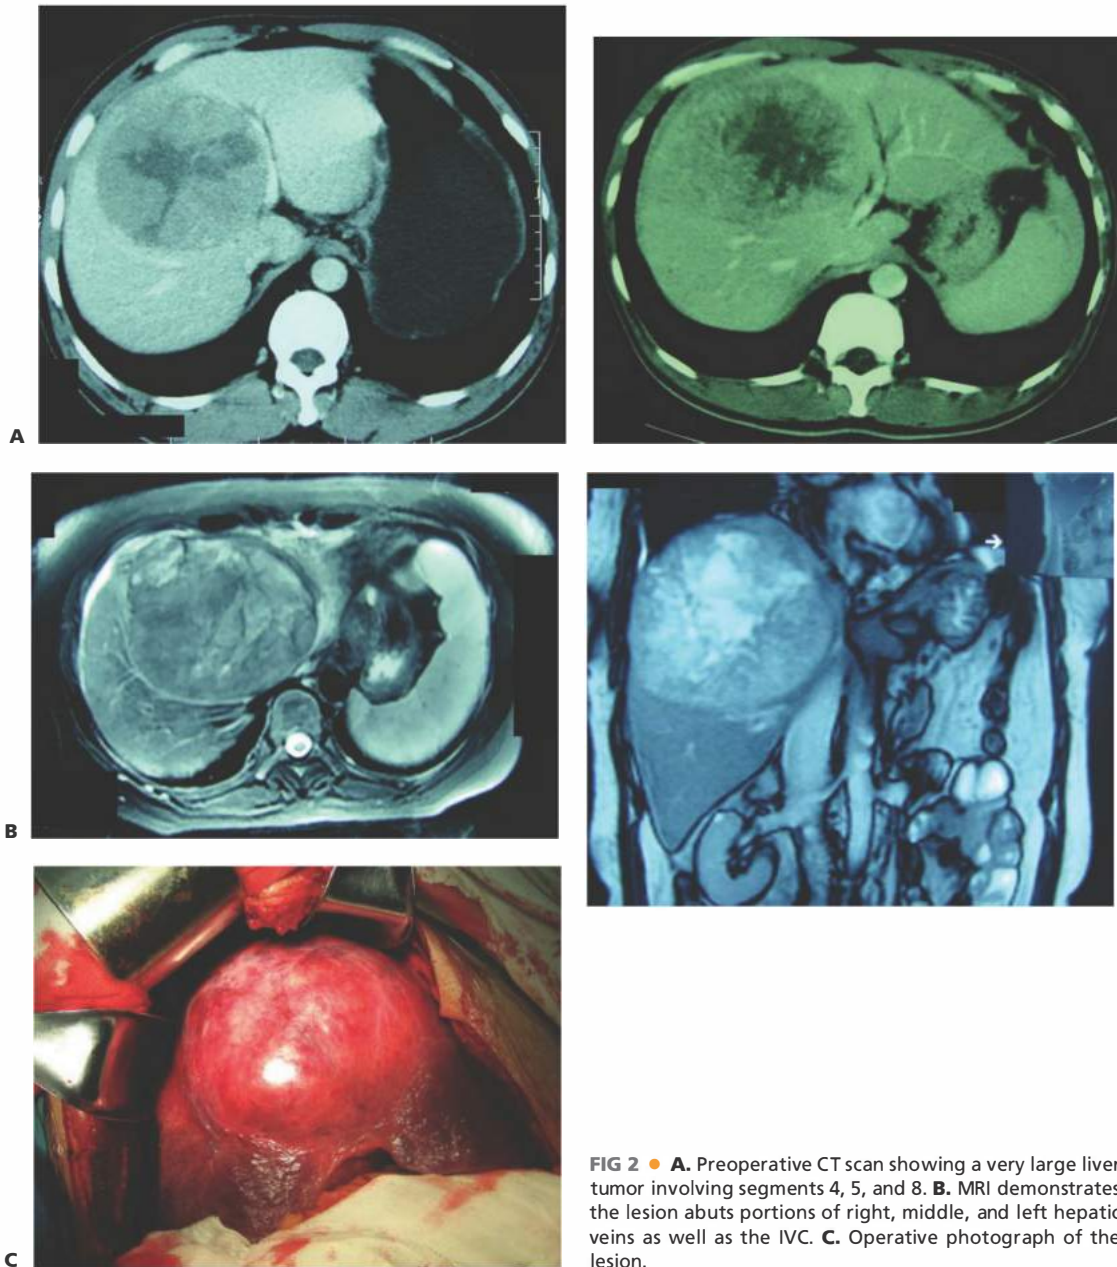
• A. Preoperative CT scan showing a very large liver tumor involving segments 4, 5, and 8. B. MRI demonstrates the lesion abuts portions of right, middle, and left hepatic veins as well as the IVC. C. Operative photograph of the lesion.
